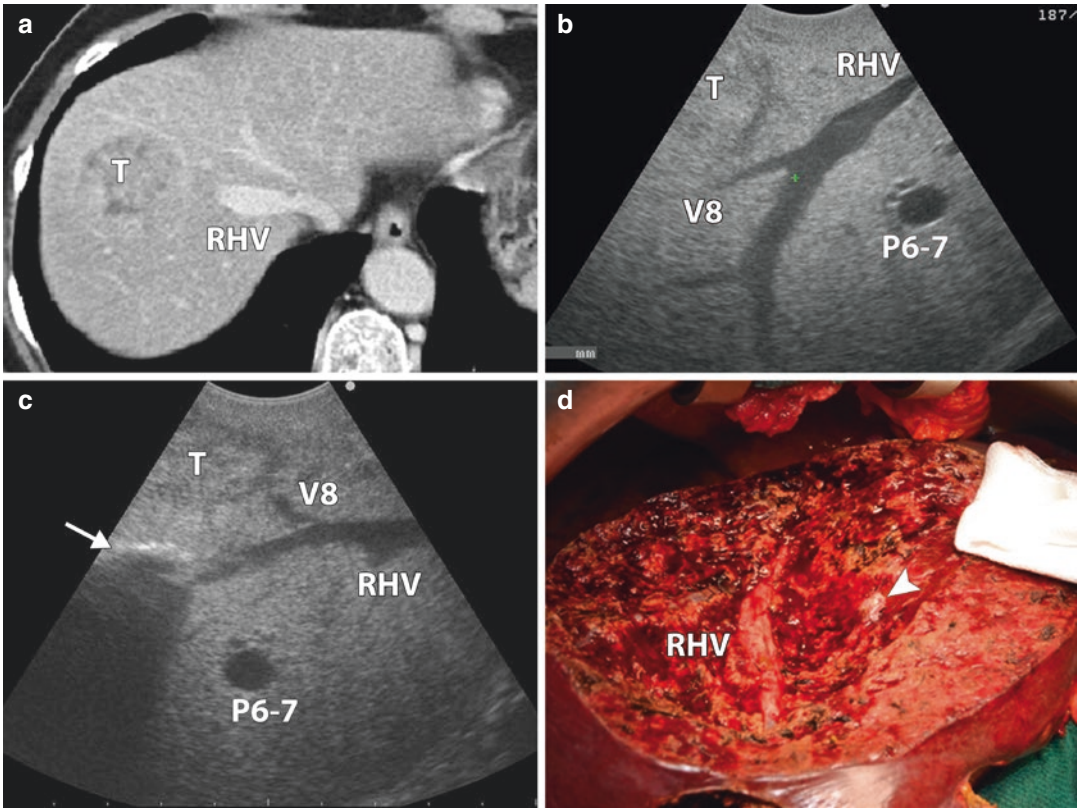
(a) CT scan showing a colorectal liver metastases (*T*) in Sg8 close to right hepatic vein (*RHV*). (b) IOUS: the lesion has no relationships with *RHV* but is in contact with a venous branch draining Sg8 (*V8*). Beneath *RHV* right posterior glissonean pedicle (*P6-7*) can be visualized. (c) IOUS real-time monitoring of the surgical plane.
